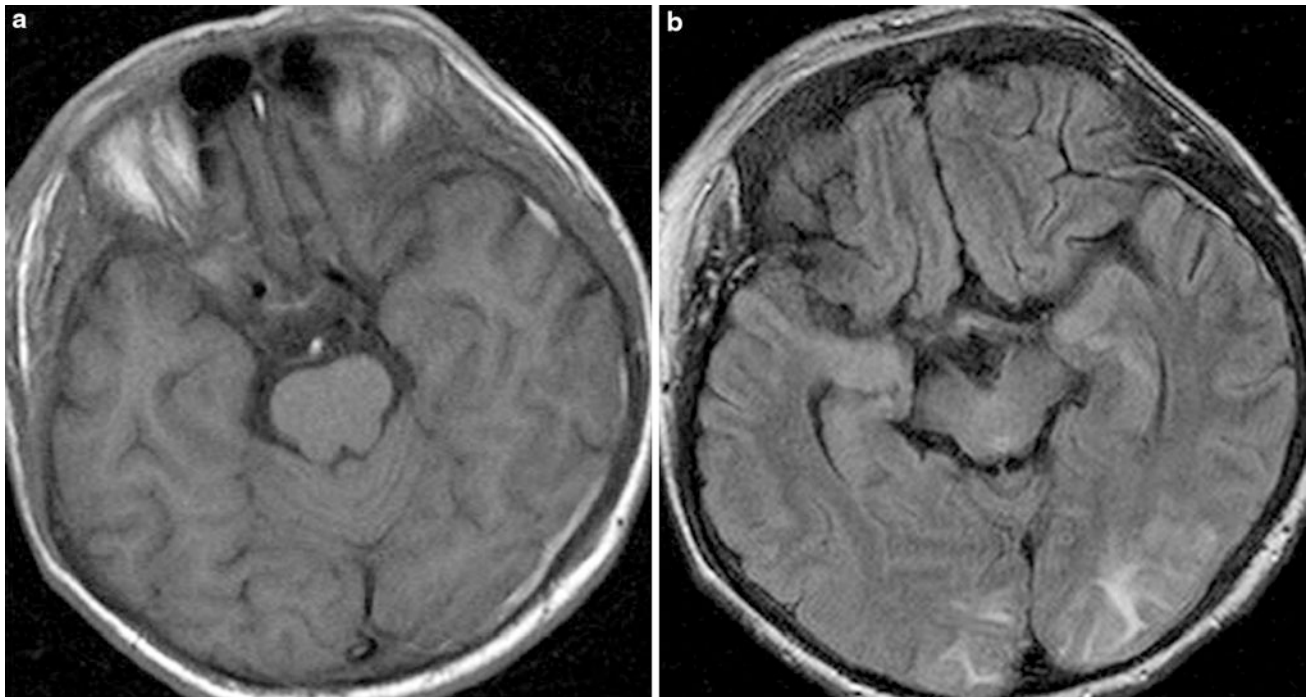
Viral vasculitis (*Varicella zoster*). A 37-year-old immuno-compromised man with ophthalmic zoster presenting with alternating phases of reduced vigilance and severe agitation. In the CSF *Varicella* viruses were found (as confirmed by PCR). a Axial T1-weighted image. b Axial FLAIR image. Left temporal acute, T1-hyperintense
